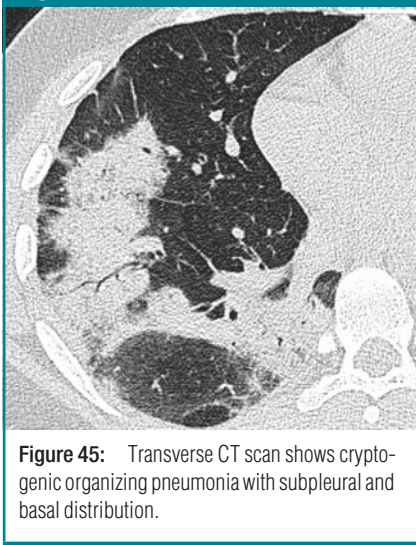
Transverse CT scan shows cryptogenic organizing pneumonia with subpleural and basal distribution.
